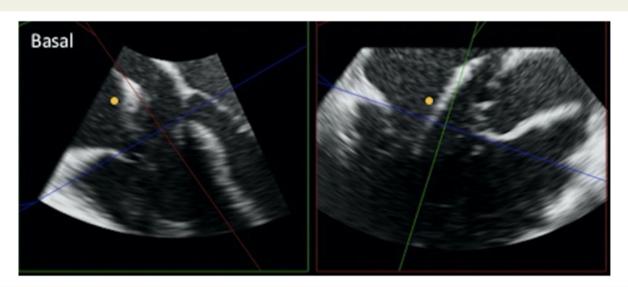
Figure I Three-dimensional transoesophageal echocardiography volumetric acquisitions allowed formation of multiplanar reconstructions of the tricuspid valve in full, from two orthogonal long-axis and resultant short-axis constructed en-face views at all levels within the valve. This image shows the multiplanar reconstruction at valve base level ('basal') and its component orthogonal long-axis images. The resultant short-axis constructed enface image will be formed from the blue crosshair line of plane, and at its level in the valve complex (annulus to tips axis). The pacemaker ventricular lead is labelled with a yellow dot.
